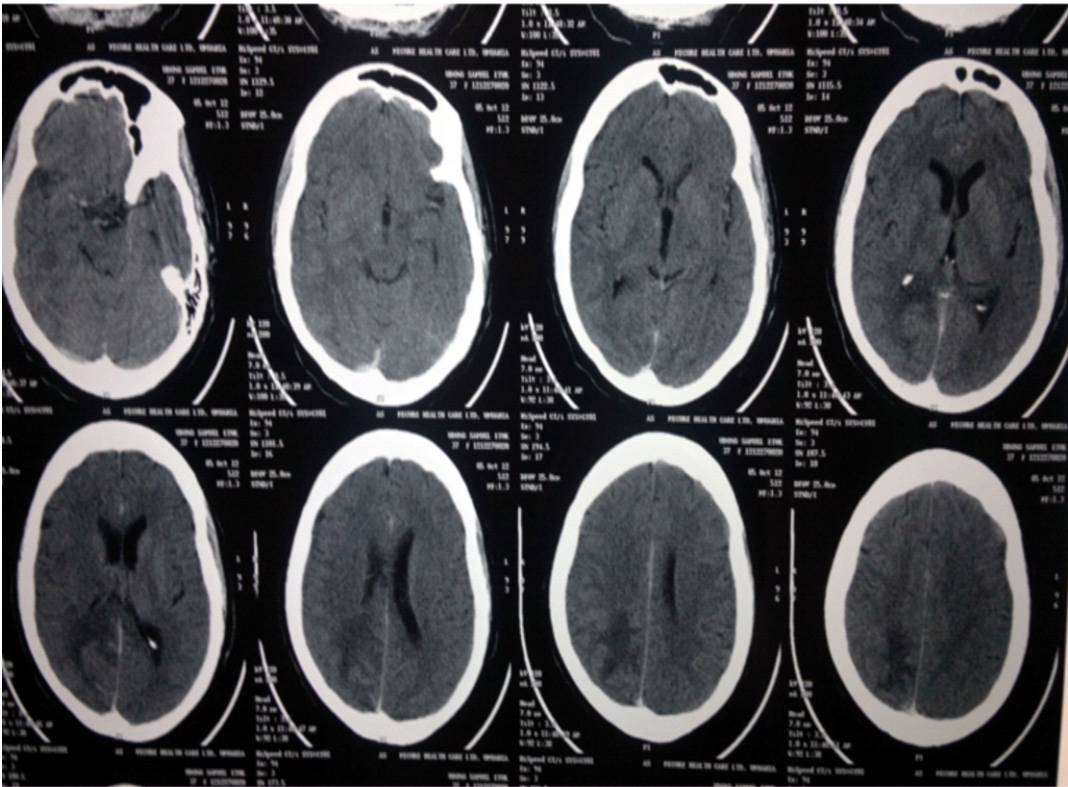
Brain CT scans of Case 1 showing non-enhancing hypodense white matter lesion in the right parieto-occipital region
